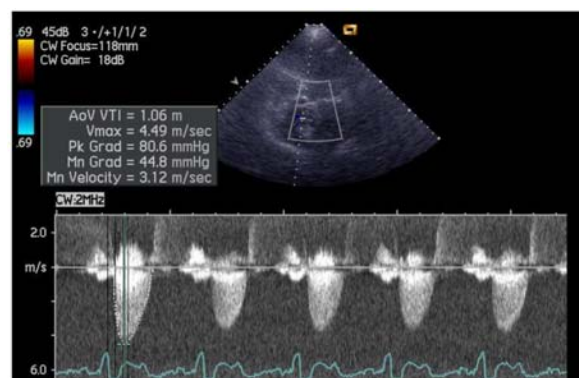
Transthoracic echocardiography – gradient across the aortic valve before transcatheter aortic valve implantation.
